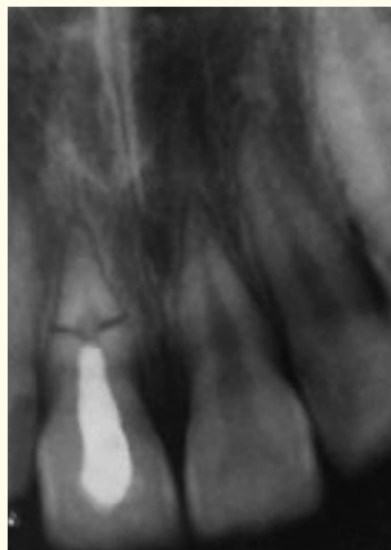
Periapical radiographic showing no changes in the apical third of the root after 6 months.
